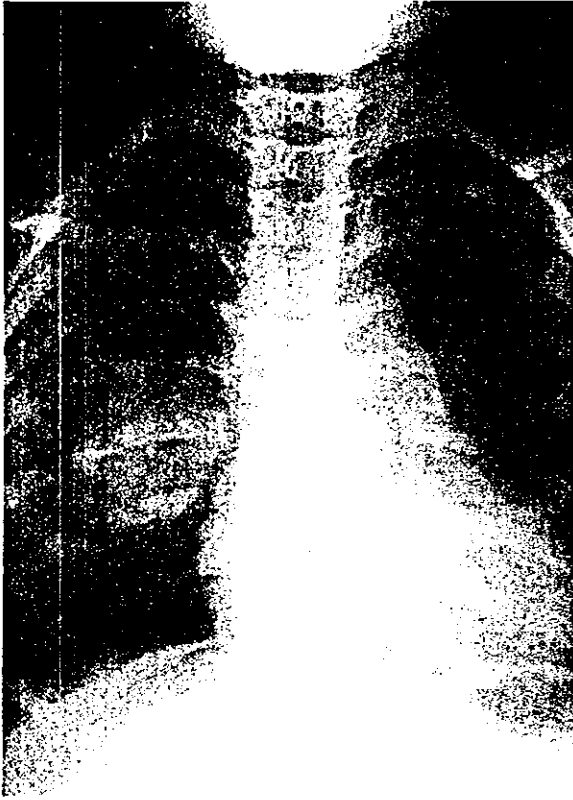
Two years after bone marrow transplantation, a chest X-ray film showed a mass lesion in the hilum of the right lung and the mediastinum.
